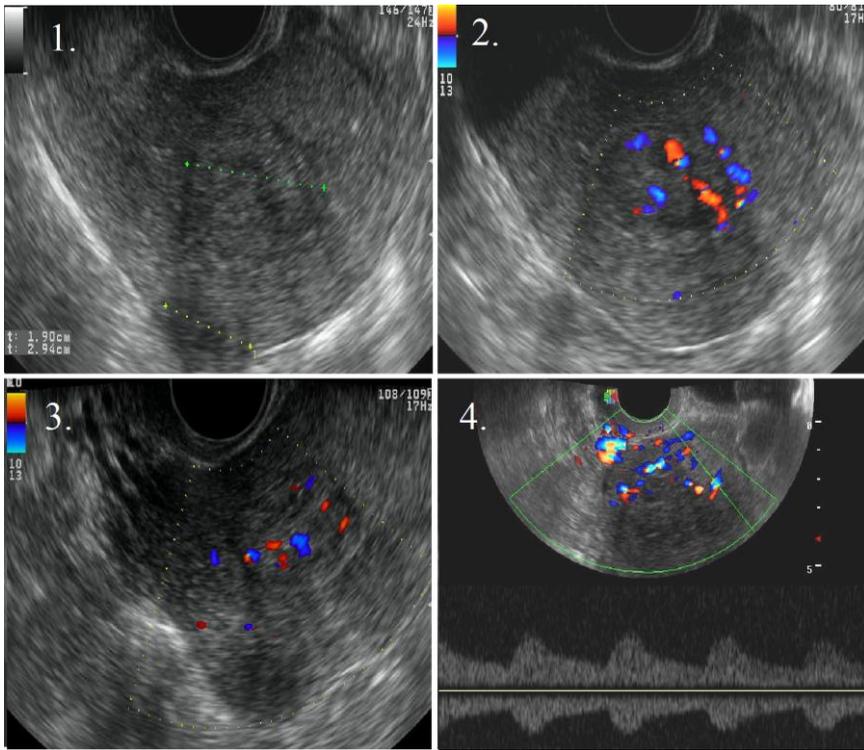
Hyperechogenic nodular images paracavitary and subserous – endovaginal examination(1)Doppler signal increased inside the nodule(2) Myometrial vascularization of normal aspect(3) Low resistance blood flow in the arcuate arteries(4)
